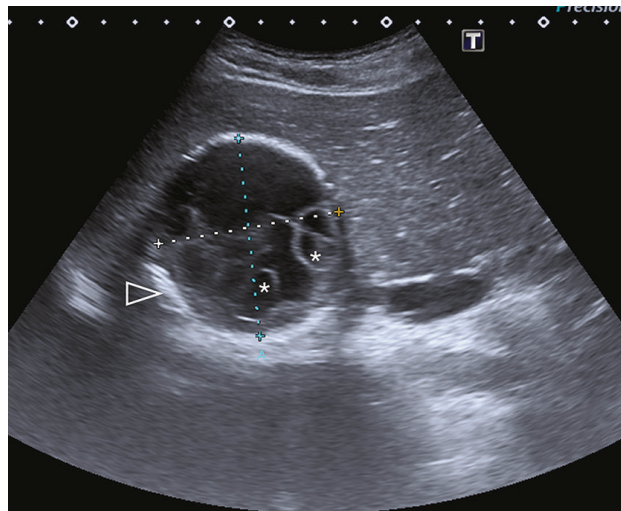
Abdominal ultrasound in a 14-year-old patient with generalized abdominal pain associated with vomiting shows a focal anechoic lesion in the right lobe of the liver, with multiple cystic images inside (asterisks) and thickened echogenic wall (arrowhead). Gharbi type III-CE2.
